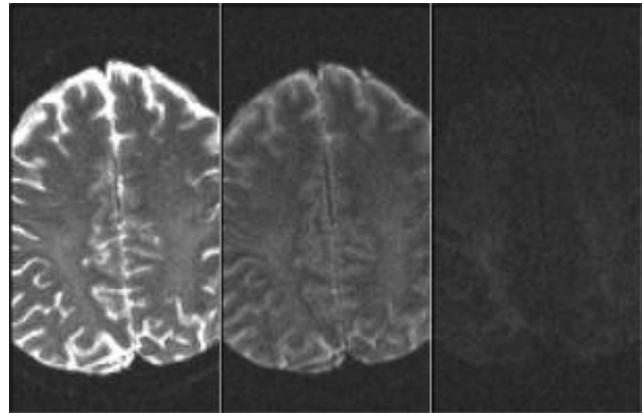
Diffusion weighted MR images of a volunteer at b-values of 50, 450 and 2100 s/mm^2 . For comparison, all images are shown with the same window adjustments.
